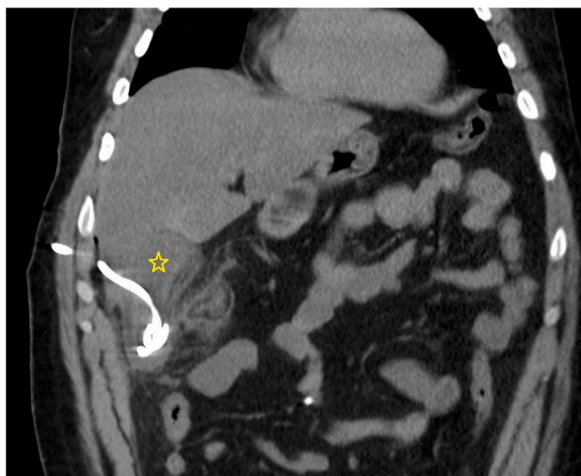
In this computed tomography image of the patient whose pain was relieved significantly 1 h after insertion of the 8F 25 cm all-purpose drainage (APD) pigtail catheter. The catheter has traversed segment VI and reached the lumen of the gallbladder. The extensive hydrops of the gallbladder has decreased significantly (star), but severe inflammation persists in the soft tissue planes around the gallbladder wall (white streaks in the adipose tissue).
